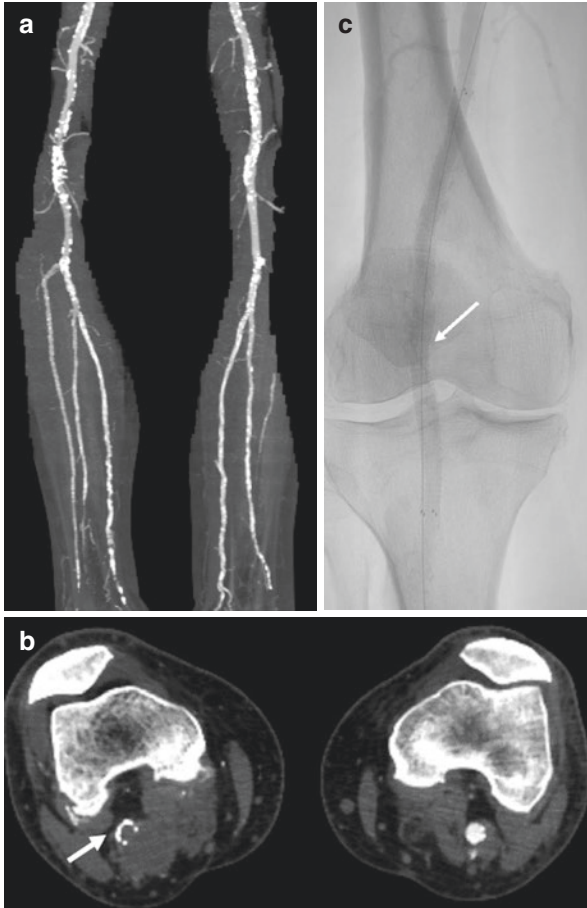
(a) CTA Maximum intensity projection (MIP) imaging through the knee reveals calcified vessels but no definite above knee disease. Occlusive and calcified distal crural disease is noted. (b) An unenhanced axial source image revealing a large popliteal aneurysm on the right (arrow)—inspection of source images and soft surroundings are essential to correct interpretation—this is especially true when luminal imaging or display techniques are used for viewing the data. In this patient although there is diabetic vasculopathy, embolism from the popliteal aneurysm was the clinical issue requiring a different treatment approach. (c) Post treatment angiography showing recanalization of the popliteal artery occlusion (arrow) and insertion of a covered stent for popliteal artery aneurysm. Luminal imaging only could have resulted in inappropriate balloon angioplasty with possible disastrous consequences from distal embolisation
